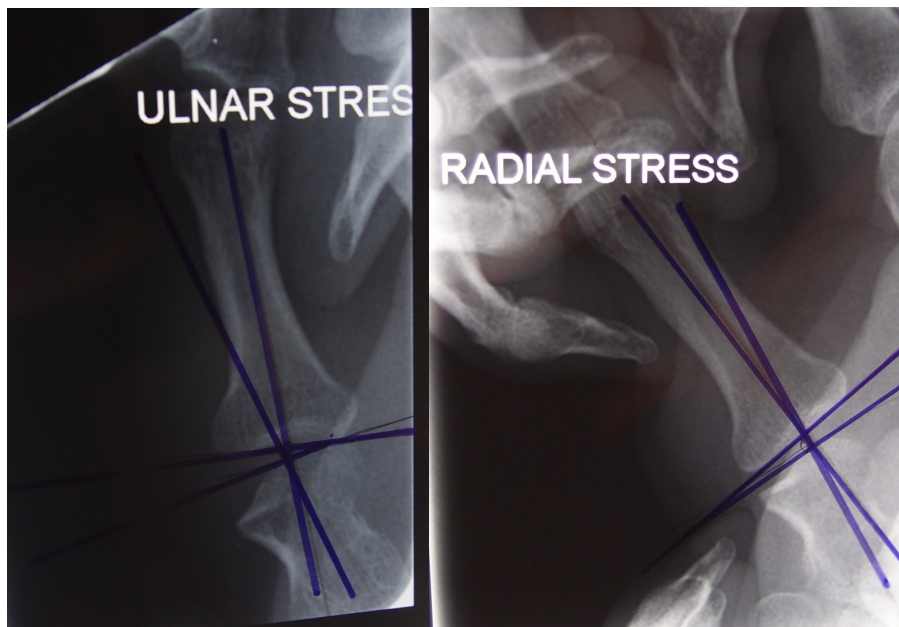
Measurement of angulation on a radiograph.
